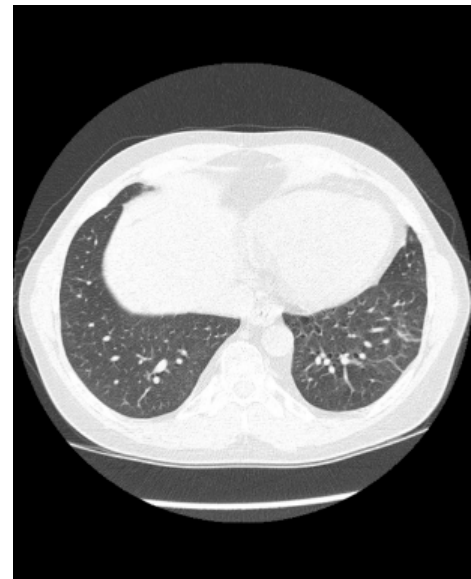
Follow-up CT scan after change of medication After suspension of Everolimus all inflammatory reactions of the lung resolved without any residues.
